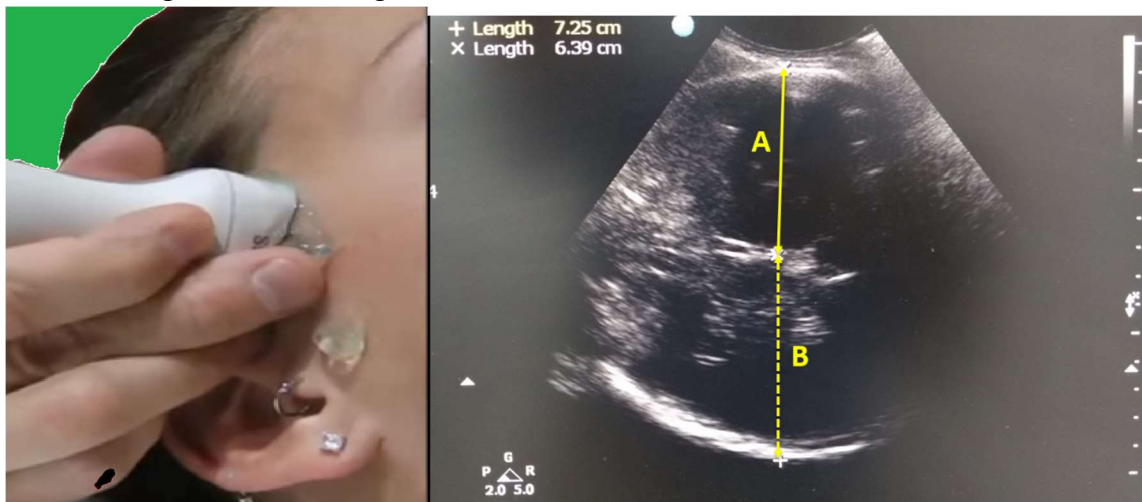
Figure showing placement of Ultrasound probe over Temporal bone (Left), Figure showing Ultrasound image with third ventricle in the center and measurement of MLS (Right). (A- Measurement on ipsilateral side third ventricle distance from skull bone, B- Measurement of distance from third ventricle to contralateral side of skull bone).
